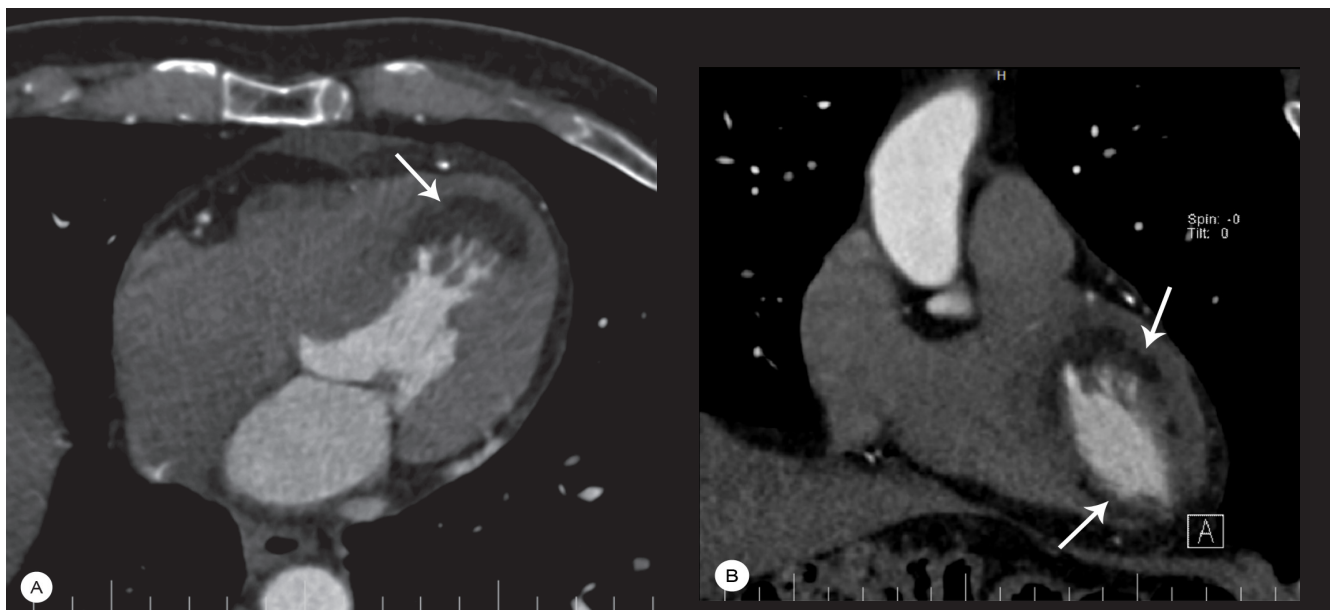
The images present the patient's computed tomography angiography, showing myocardial lipomatous metaplasia in the axial and coronal views.
